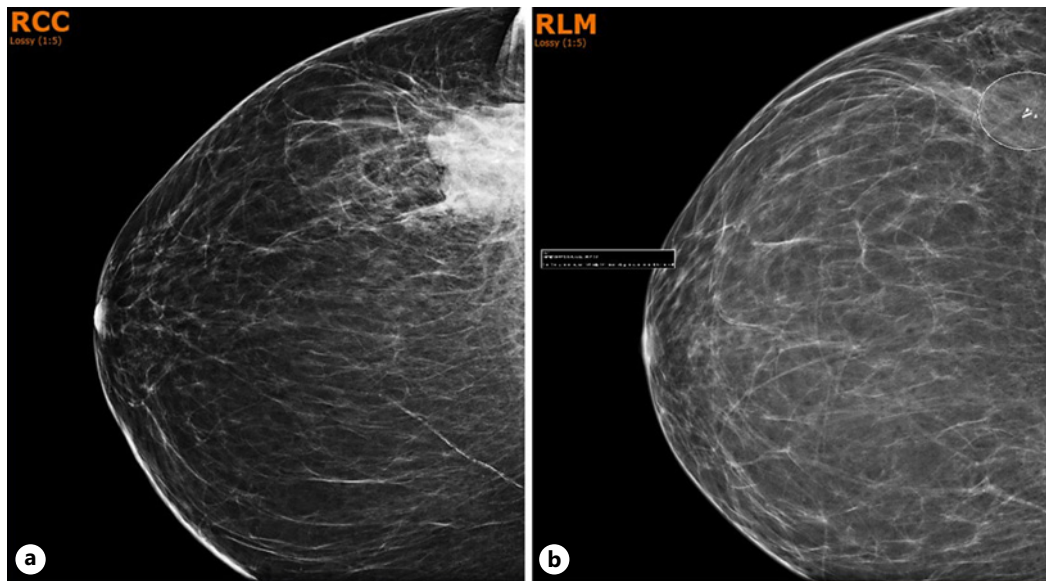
Radiographic response to neoadjuvant chemotherapy. a Mammogram image at time of diagnosis showing an irregularly shaped mass. b Mammogram after conclusion of neo-adjuvant chemotherapy (clip and seed in place immediately prior to lumpectomy). Concentric shrinkage of the mass is apparent by a mammogram.
